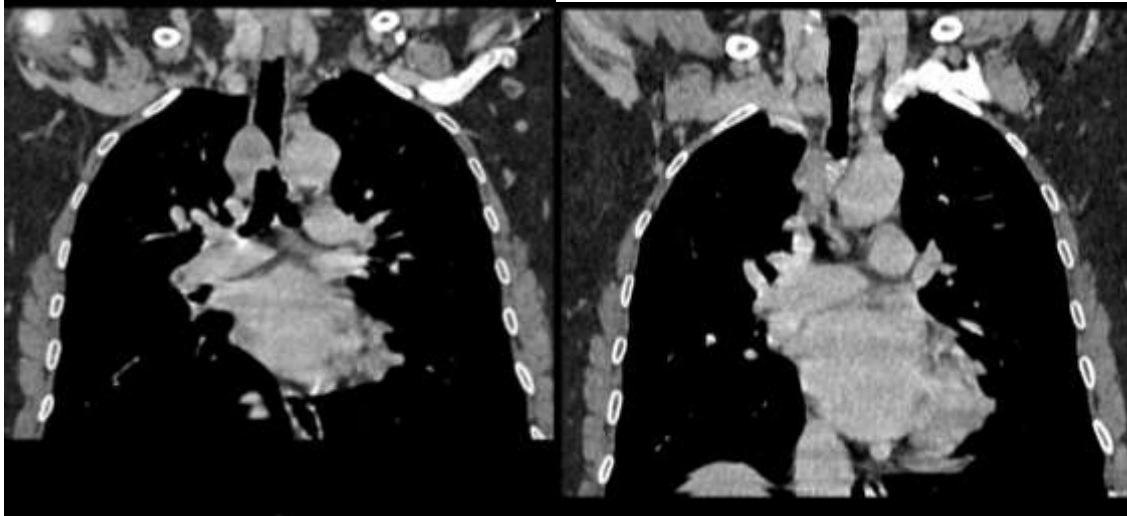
(A, B):- Chest CT Scan in Mediastinal Window, Coronal Section showing thickening of the right lateral wall of the trachea responsible for stenosis.
